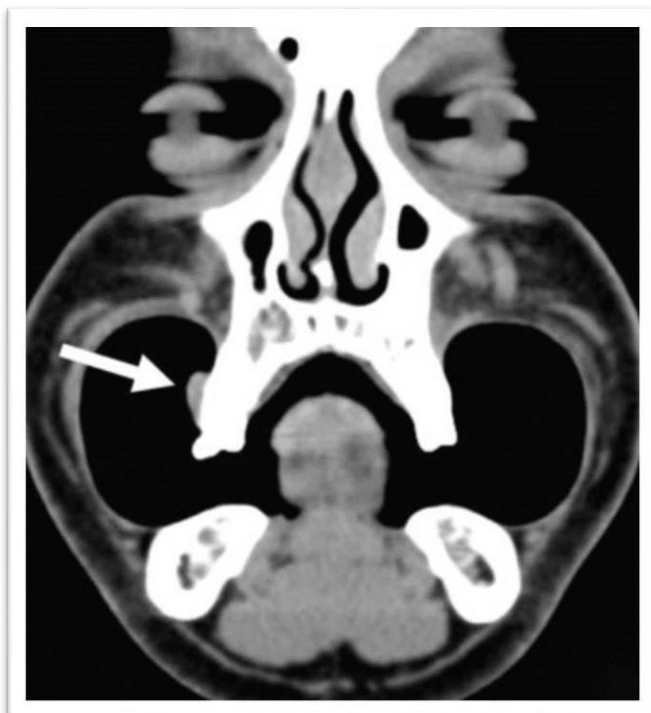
Coronal section of CT with soft tissue window indicating enlargement of the buccal gingiva of the maxillary right side. Coronal section of CT with soft tissue window indicating enlargement of the buccal gingiva of the maxillary right side. Adapted from: Law CP et al. (90)
